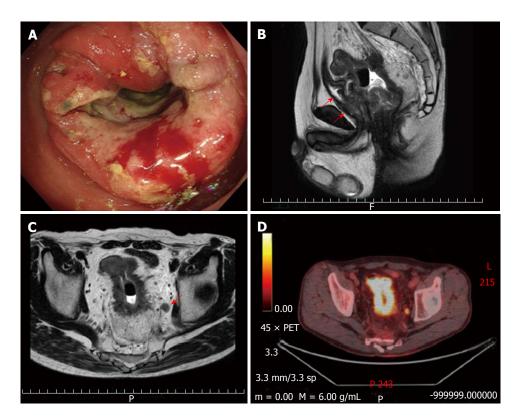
Evaluation of clinical findings. Colonoscopy showed a circumferential mass at the lower rectum (A); Sagittal magnetic resonance imaging (MRI) of the pelvis showed rectal mass with involvement prostate and seminal vesicles (red arrows) (B), and perirectal fat (C); The enlarged lymph node in the left obturator detected by coronal MRI (red arrow) showed obvious metabolically active foci 18-fluorodeoxyglucose-positron emission tomography/computed tomography evaluation (D).
